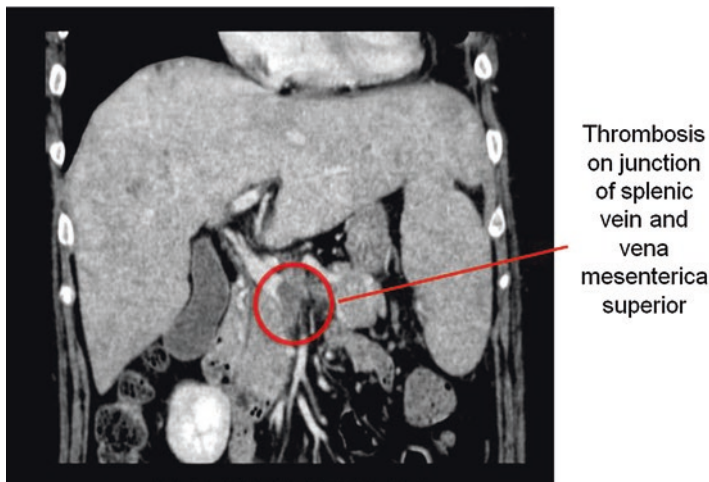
Contrast-enhanced CT scan of the abdomen of a patient with PNH (37-year-old female with 14-year history of PNH). An extensive thrombosis in splenic vein was revealed. This patient was then treated with eculizumab. 14 weeks after the eculizumab administration, splenic vein thrombosis disappeared. (This CT is kindly provided with permission by Dr. Shinya Katsutani, Hiroshima University Hospital, Hiroshima, Japan)
